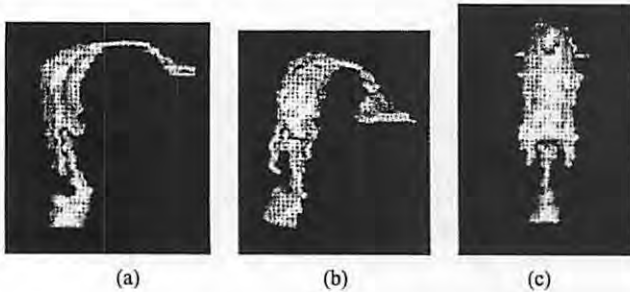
Shaded surface displays of the vowel /i/ using the MR image set: a, b, and c) various projections of the airway.
